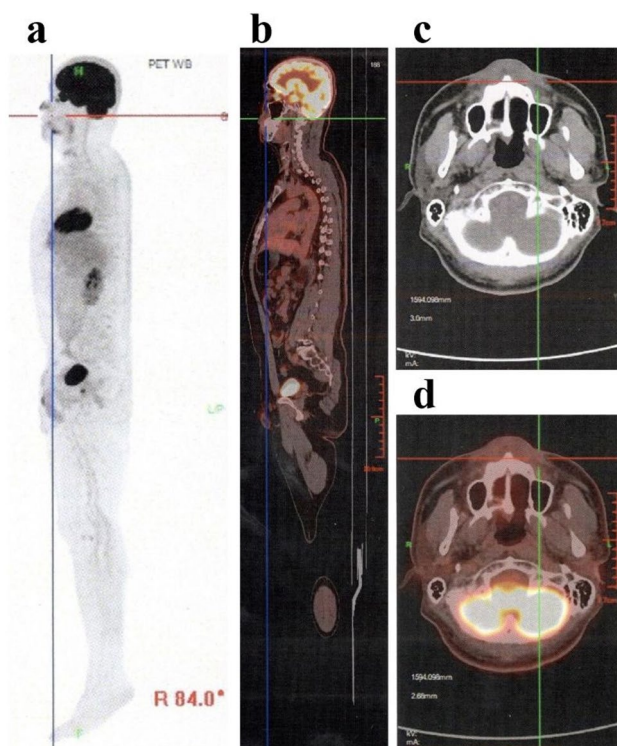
PET/CT findings at eight-month follow-up. a Whole-body sagittal PET image showing no hypermetabolic activity in the left upper lip region compared with the initial PET/CT. b Sagittal PET/CT fusion image confirming the absence of abnormal FDG uptake in the left upper lip. c Axial CT image of the upper lip showing no residual soft-tissue mass. d Axial PET/CT fusion image demonstrating no abnormal FDG uptake at the site of the original left upper lip lesion
